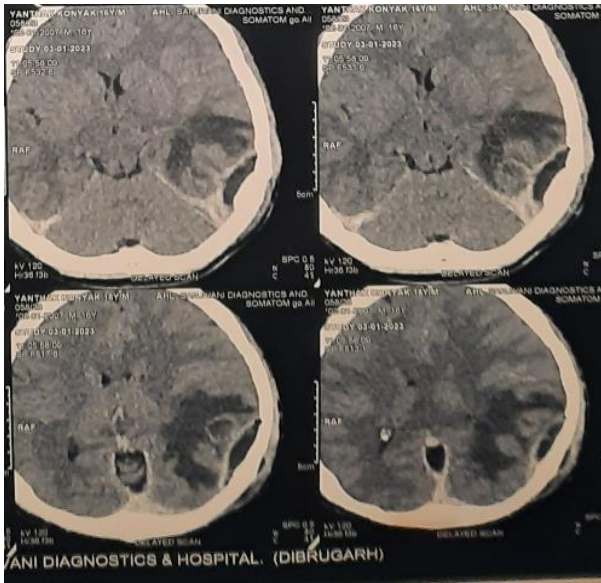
CT brain showing left temporoparietal abscess.
